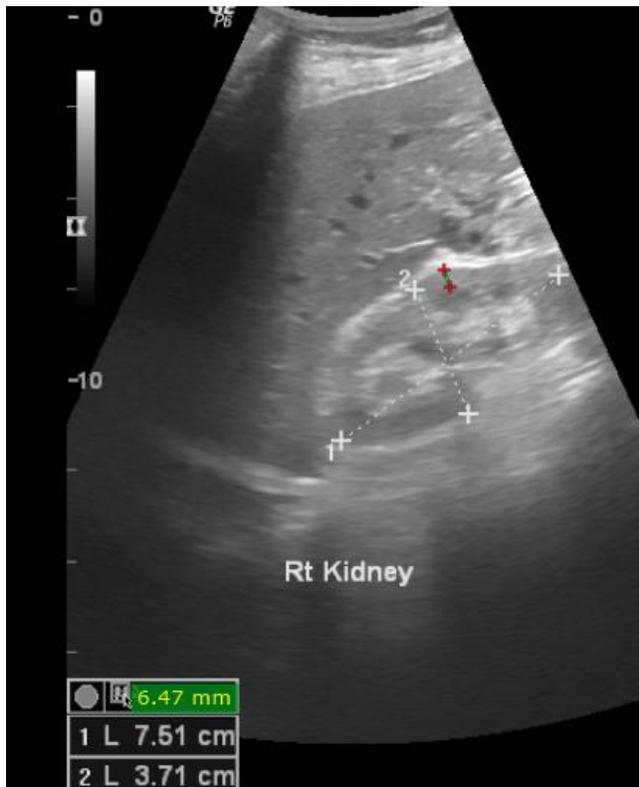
Greyscale ultrasound scan of the right kidney of a 73 year-old, female hypertensive and CKD patient showing BPL (white callipers 1) and RCT (red callipers).
